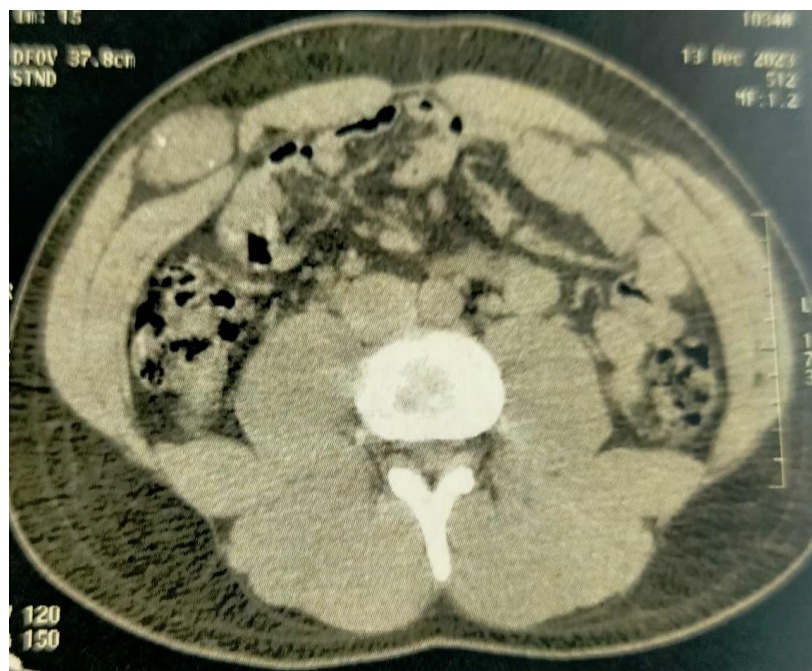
CT Scan Section Showing the Abdominal Wall Mass
